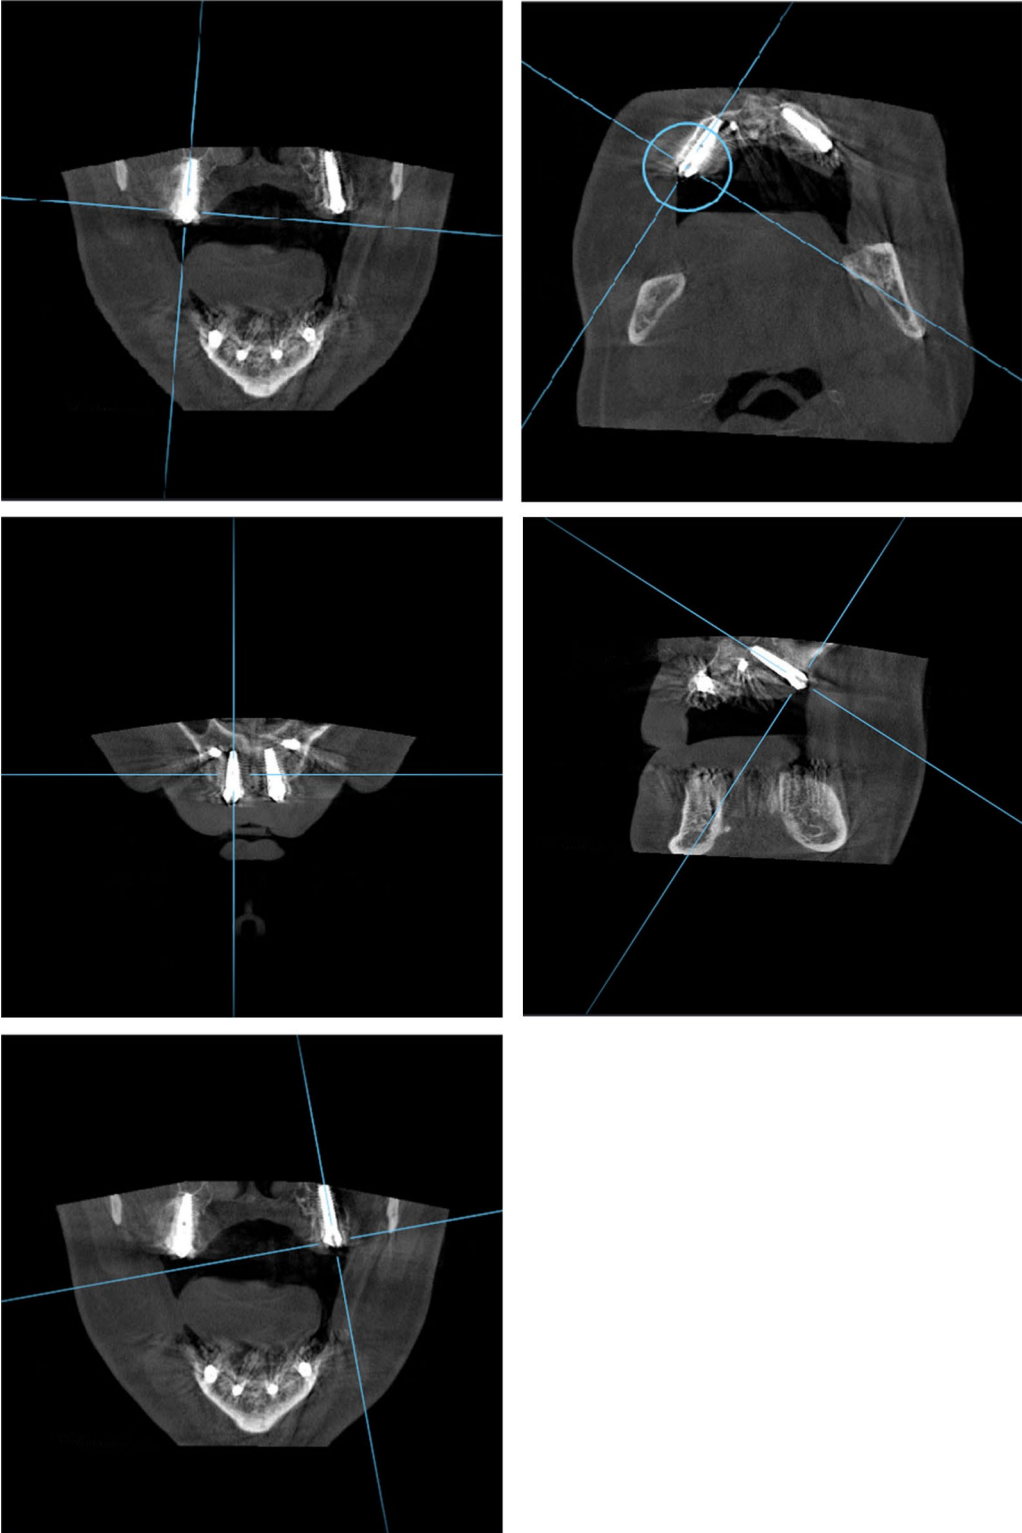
CBCT scan was taken immediately after implant placement
